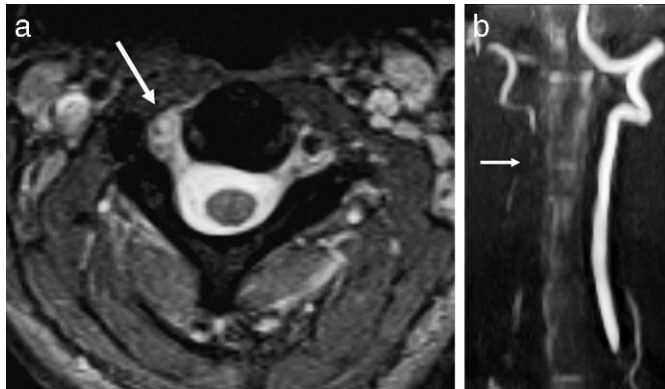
Vertebral artery injury. (a) Axial T2-weighted image demonstrates loss of the normal flow void within the right vertebral artery consistent with dissection (arrow). Note the normal dark flow void in the left vertebral artery. (b) This was confirmed on a coronal maximum intensity projection view with MR angiography (arrow).
